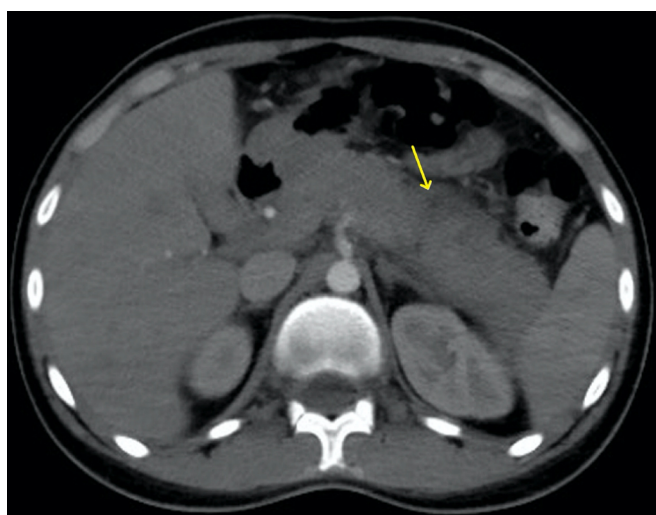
Follow-up contrast-enhanced CT shows increased conspicuity and clearer demarcation of the hypodense necrotic pancreatic areas (yellow arrows), with persistent peripancreatic inflammatory changes.
